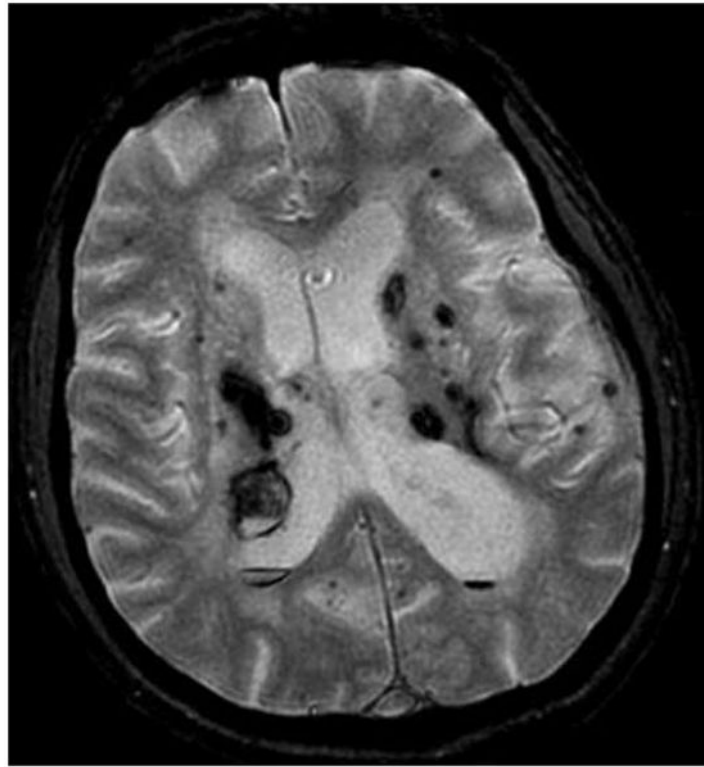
A T2*GRE MR image showing multifocal hemorrhagic lesions in an elderly patient with previous strokes, including recent intracerebral hemorrhages associated with untreated hypertension. The T2*GRE MR imaging sequences revealed multifocal occult tiny hemorrhagic lesions, interpreted as hypertensive angiopathy. These are differentiated from familial CCM disease by the clinical setting and by the clustering of lesions in periventricular areas most vulnerable to hypertensive angiopathy. Conversely, CCM disease is associated with lesions in a volume distribution throughout the brain.
